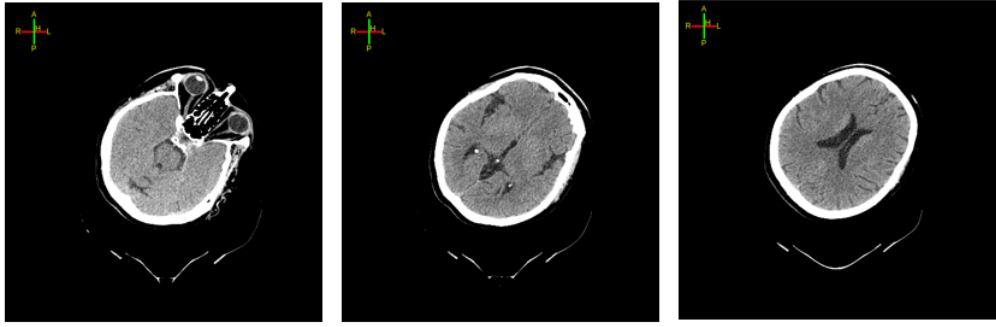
CT image of head at different slices.
